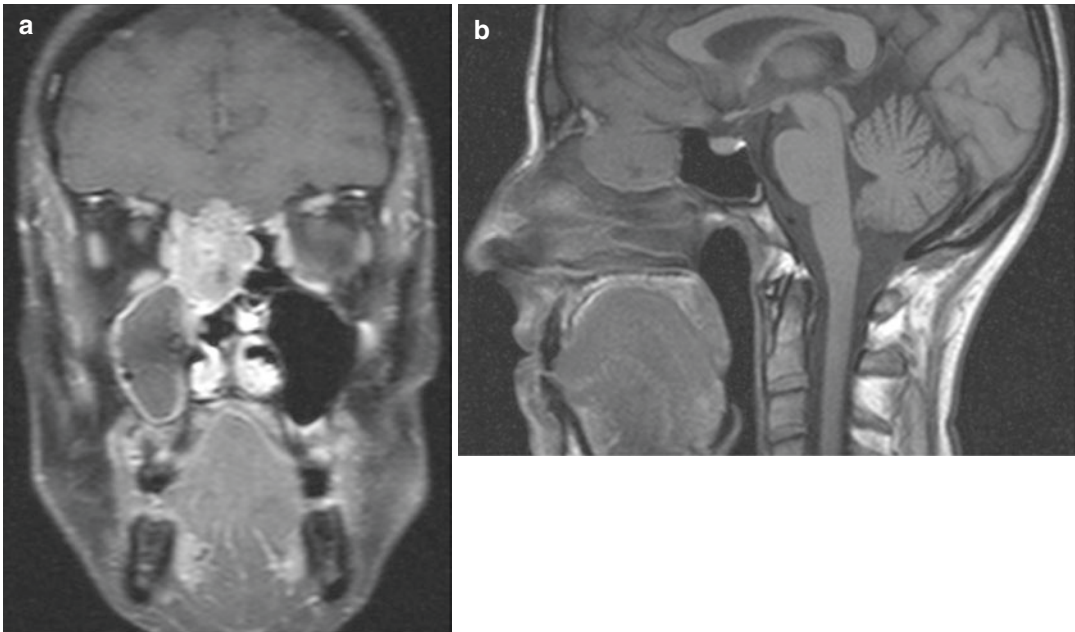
(a) Coronal T1-weighted gadolinium enhanced MRI. There is tumor in the right ethmoidal cells with invasion of the anterior cranial fossa, without enhancement of the dura nor infiltration of the brain. Lateral compression of the orbit without infiltration. The middle
